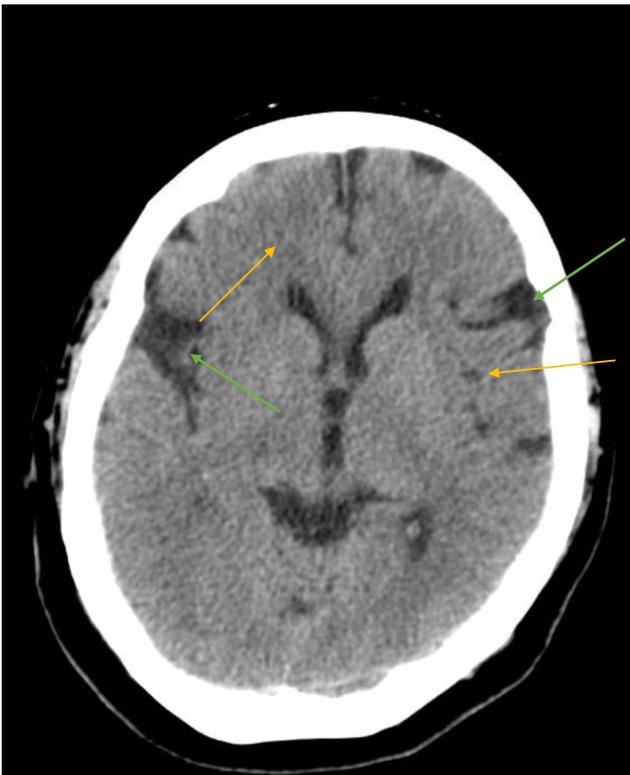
Unenhanced axial computed tomography image at the level of the cerebellar vermis of a patient with white matter changes (yellow arrows) and cerebral atrophy demonstrated with more prominent cerebral sulci (green arrows)
